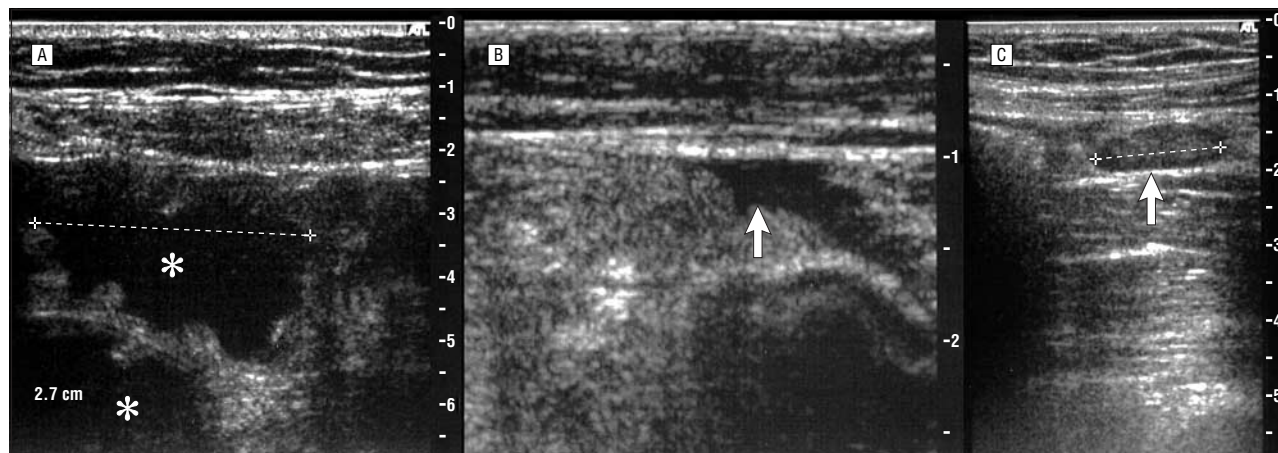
Ultrasound pictures obtained from a patient with celiac disease showing (asterisks and arrows) dilated small bowel loops with increased fluid content (A), free abdominal fluid (B), and enlarged mesenteric lymph node (C).
